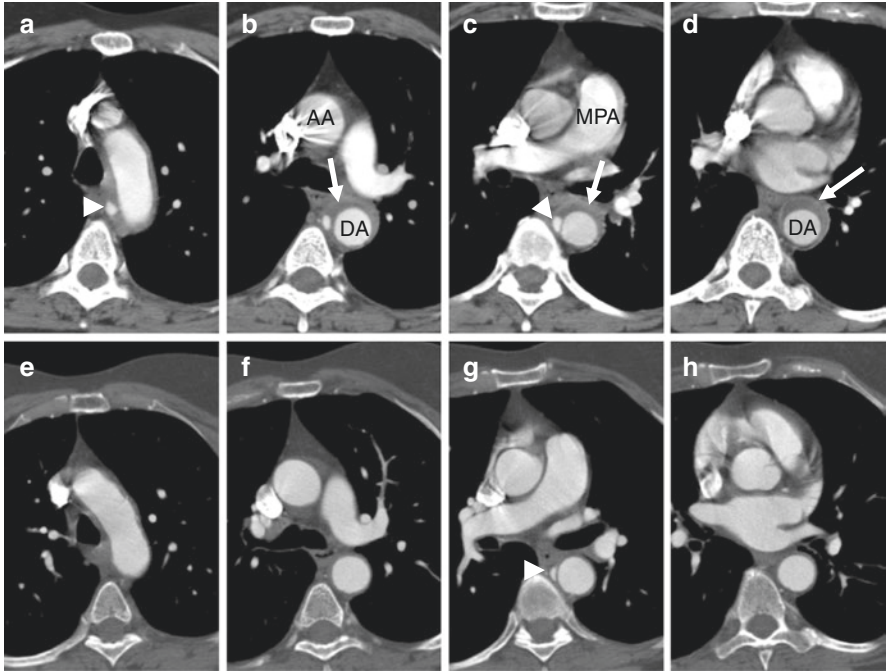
Type B IMH in a 57-year old woman with a few days of chest and back pain. Transaxial CT images (a–d) obtained on the same day as the MRI study in figure 9 and 3 years later (e–h). There is a relatively smooth low-density crescent of intramural hemorrhage (arrows) with a few intramural blood pools (IBPs) (arrowheads). Except for minimal mural thickening and a single IBP, there has been near complete resolution of the lesion on follow-up imaging. AA Ascending aorta; DA Descending aorta; MPA Main pulmonary artery
